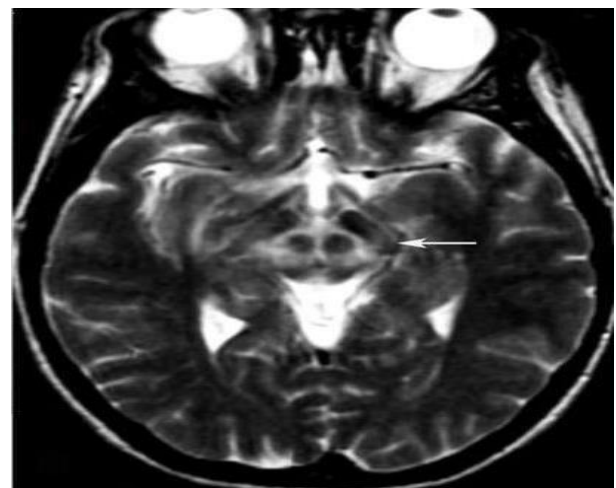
MRI T2 -weighted image.
